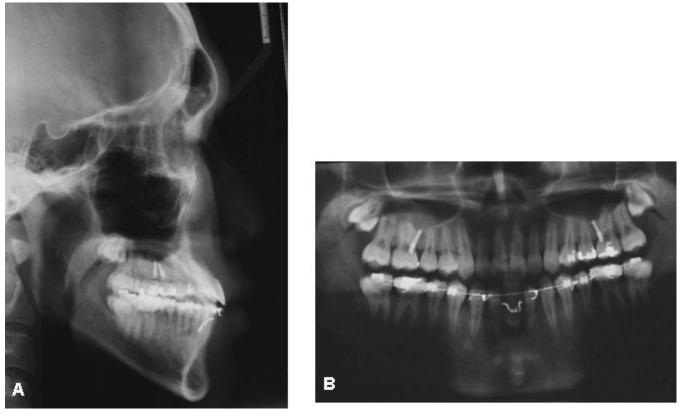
After full distalization of lower dentition, cephalometric, and panoramic radiographs.
